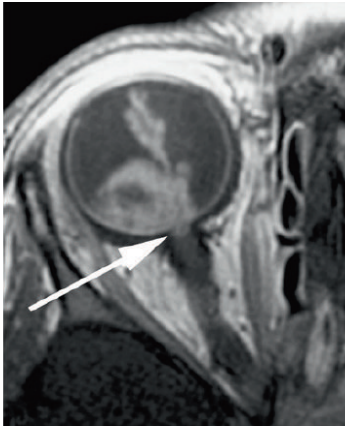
Postcontrast transaxial T1-weighted (TR/TE, 374/14 ms) MRI. Abnormal enhancement of the distal optic nerve in continuity with tumor is a sign of postlaminar optic nerve invasion
